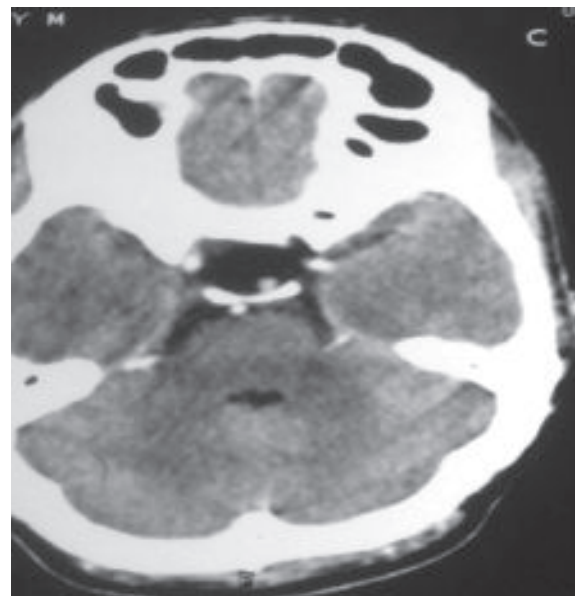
Post-operative CT Scan of Brain Axial Contrast: normal sellar and supra-sellar region.
